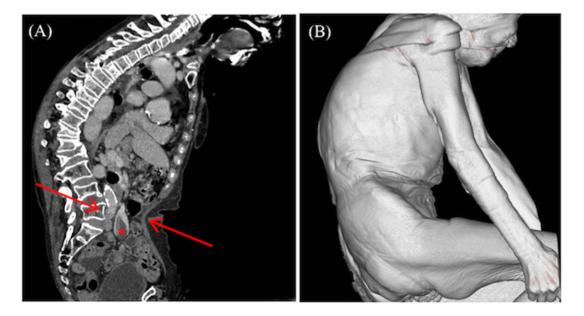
SMV thrombosis in the elderly with kyphosis. (A) Contrast-enhanced sagittal computed tomography image, showing giant SMV thrombus. The asterisk indicates the thrombus in the SMV. The arrows indicate that the SMV was physically sandwiched between the abdominal wall and the protruding part of the deformed spine. (B) Reconstructed 3D image of the patient's appearance, showing kyphosis.
